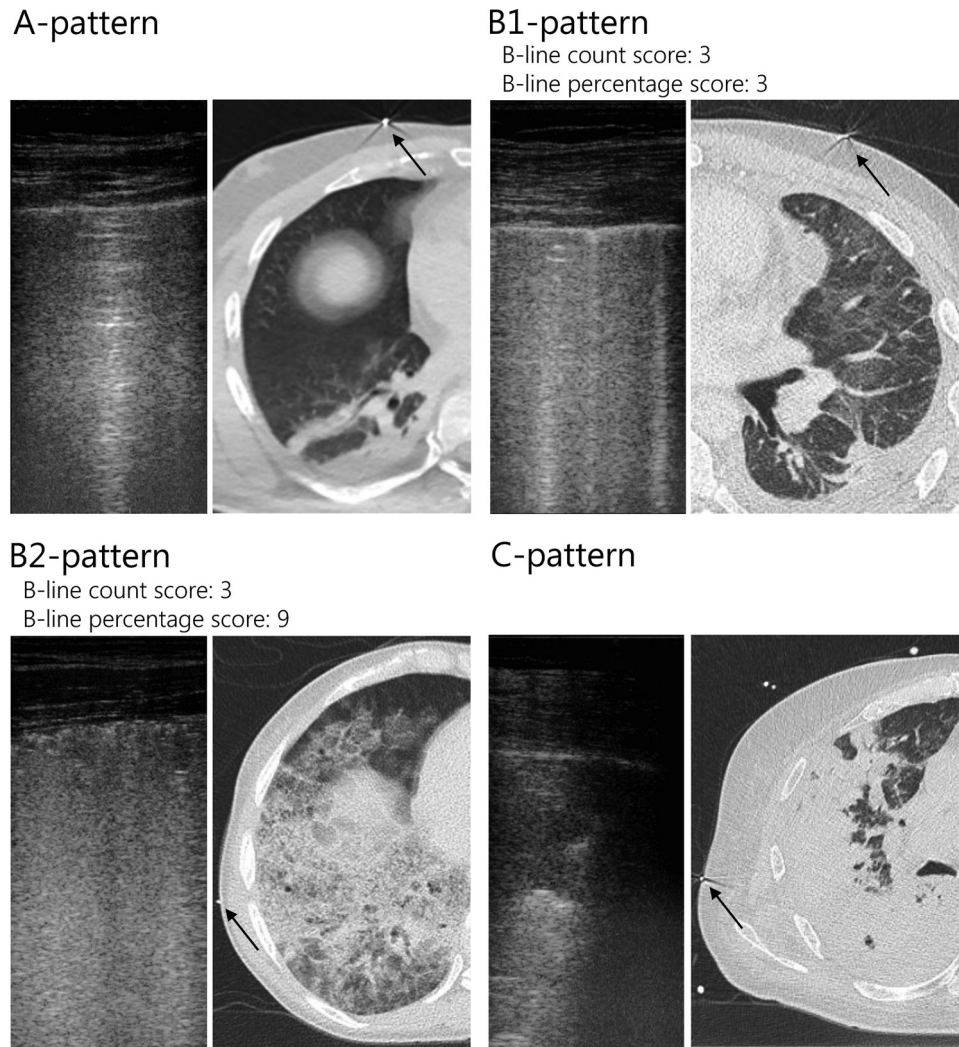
Examples of LUS images with A-, B1-, B2- and C-patterns and the corresponding CT scans. The *black arrows* in the CT scans indicate the radiopaque skin markers that were placed at the location where the LUS image was obtained. For the images with a B-pattern, the B-line count and B-line percentage score are provided. For the B-line count score, separated B-lines were counted. For the B-line percentage score, B-lines were counted when separated, but in the case of a confluent B-line pattern, the percentage of the screen covered by B-lines was estimated and divided by 10. CT = computed tomography; LUS = lung ultrasound.
